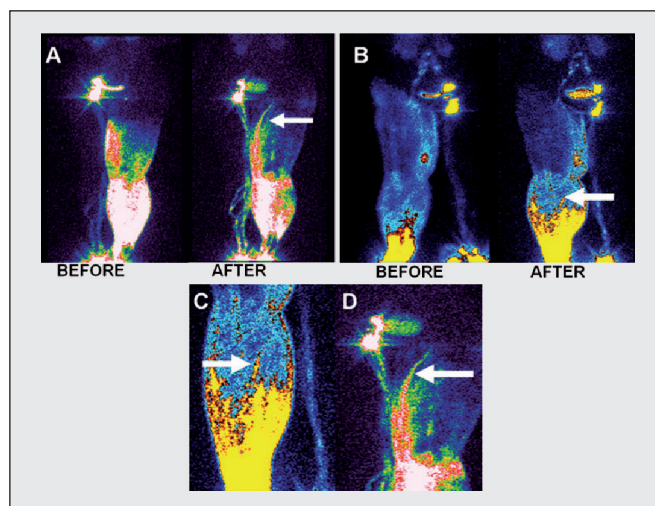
Lymphoscintigrams showing formation of tissue channels after long-lasting compression therapy. A. A channel not seen before treatment reaching groin area (arrow). B. Multiple channels in the calf at higher level than before treatment (arrow). C, D. Under higher magnification, the structure of new channels differs from that of lymphatics (arrows).
